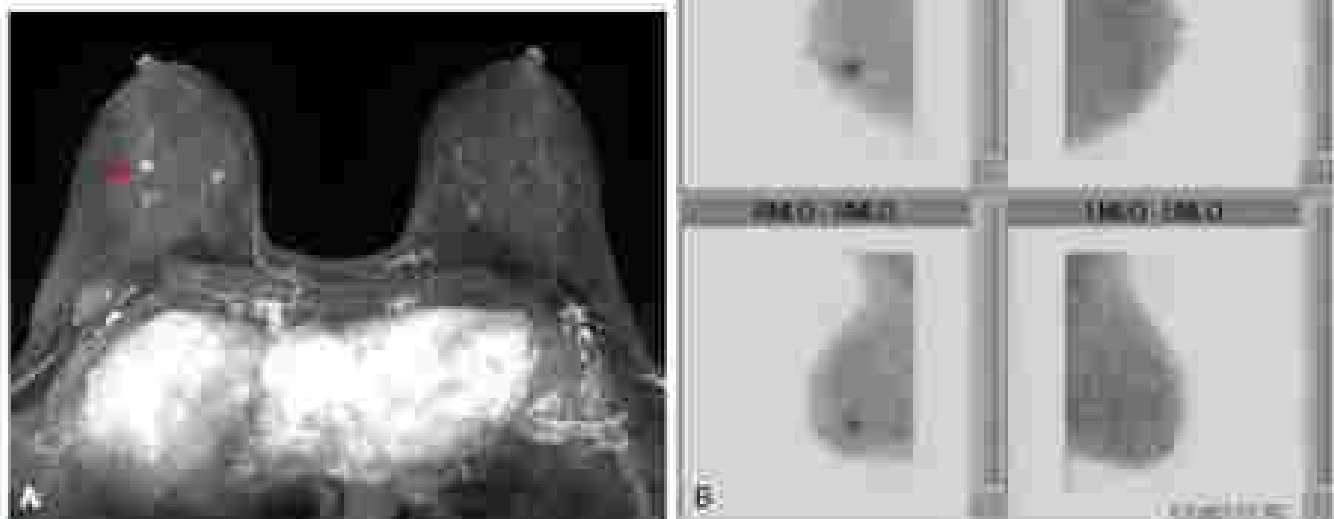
(A) A maximum intensity projection (MIP) image of a screening breast MRI showing a breast imaging portogram in a 49-year-old woman with BRCA 2 gene mutation demonstrating an 8 mm irregular enhancing mass in the right breast (4.6×2.1 cm) that was later biopsy-proven to be a grade 2 invasive ductal carcinoma, and node-negative following definitive surgical management. (B) Standard screening molecular breast imaging (MBI) images in a 49-year-old high-risk breast demonstrating focal enhancement spaces in the inner right breast, with subsequent ultrasound-guided biopsy demonstrating a grade 2 invasive ductal carcinoma.
